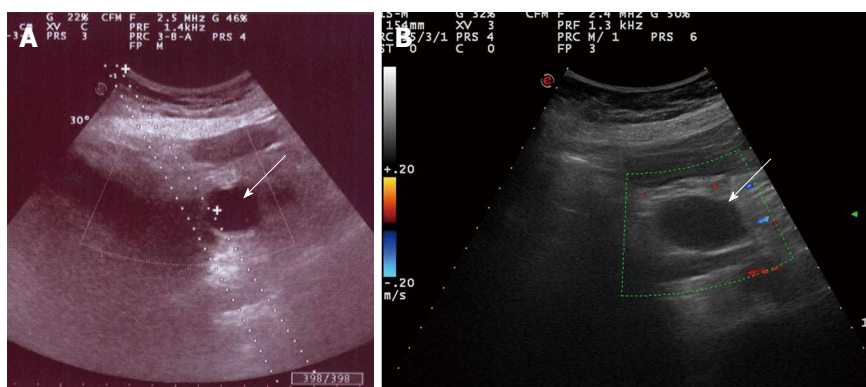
Two-dimensional B-mode ultrasonography (A) and color-Doppler ultrasonography (B) showing pancreatico-duodenal artery pseudoaneurysm (arrows) before and after percutaneous thrombin injection, respectively.
